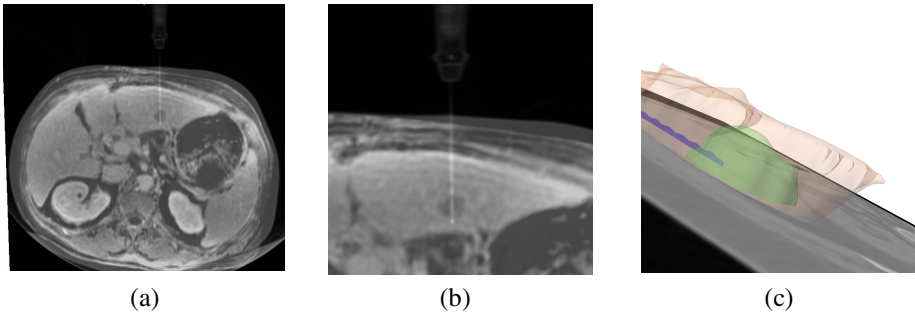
Axial images of the same patient as Figure 1. Contrast enhanced pre- MRI overlaid on intra- CT by non-rigid registration (a) and (b). The position of the RFA electrode with respect to the tumor margins can be evaluated in (c).
